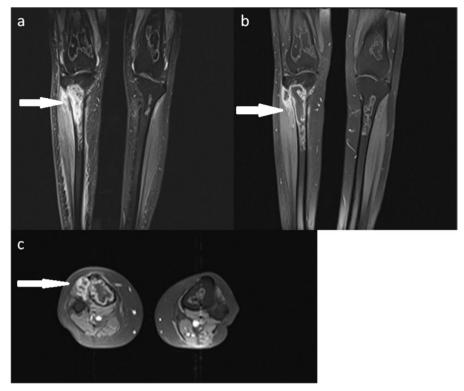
August 19, 2020: (a) Both knees and upper legs MRI showed intense peripheral and central contrast enhancement in the previously described intramedullary bone infarct in the proximal of the right tibial meta-diaphysis with focal anterior cortical disruption. Adjacent thick rim enhancement of soft tissue in the anterior tibialis muscle was in favor of osteomyelitis and a soft tissue abscess. Mild peripheral enhancement was visualized in other infarcted areas. (Arrow indicates bone involvement and soft tissue abscess). (b) Coronal MRI of both knees and upper leg. (Arrow indicates soft tissue abscess). (c) Axial MRI of both tibiae. (Arrow indicates soft tissue abscess).
